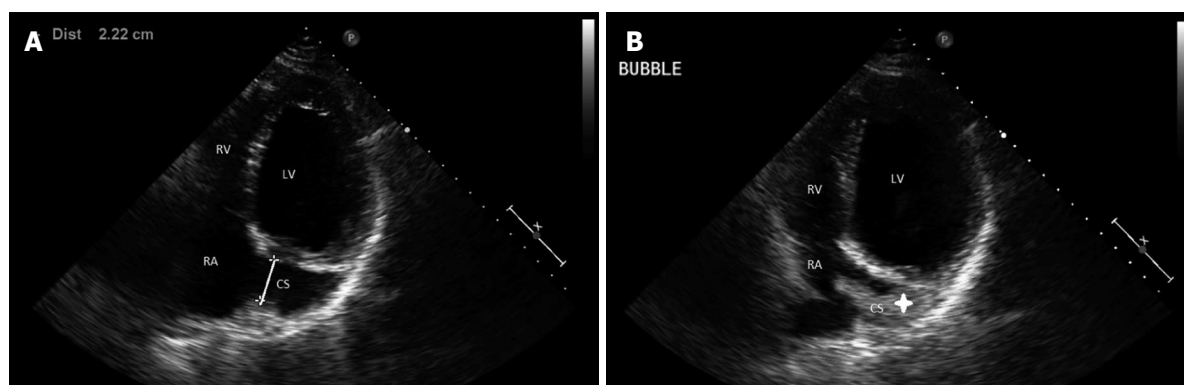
Ultrasonography. A: Modified apical 4 chamber two-dimensional echocardiographic view showing dilated coronary sinus; B: Injection of agitated saline into the left antecubital vein results in filling of the coronary sinus first (star), followed by the filling of the right atrium. CS: Coronary sinus; LV: Left ventricle; RA: Right atrium; RV: Right ventricle.
